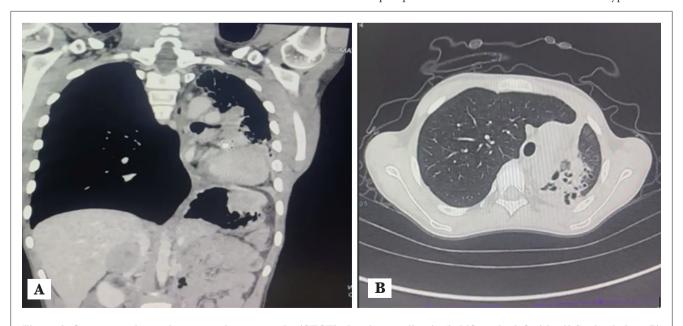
Contrast enhanced computed tomography (CECT) showing mediastinal shift to the left side. A) Sagittal view; B) Coronal view.
